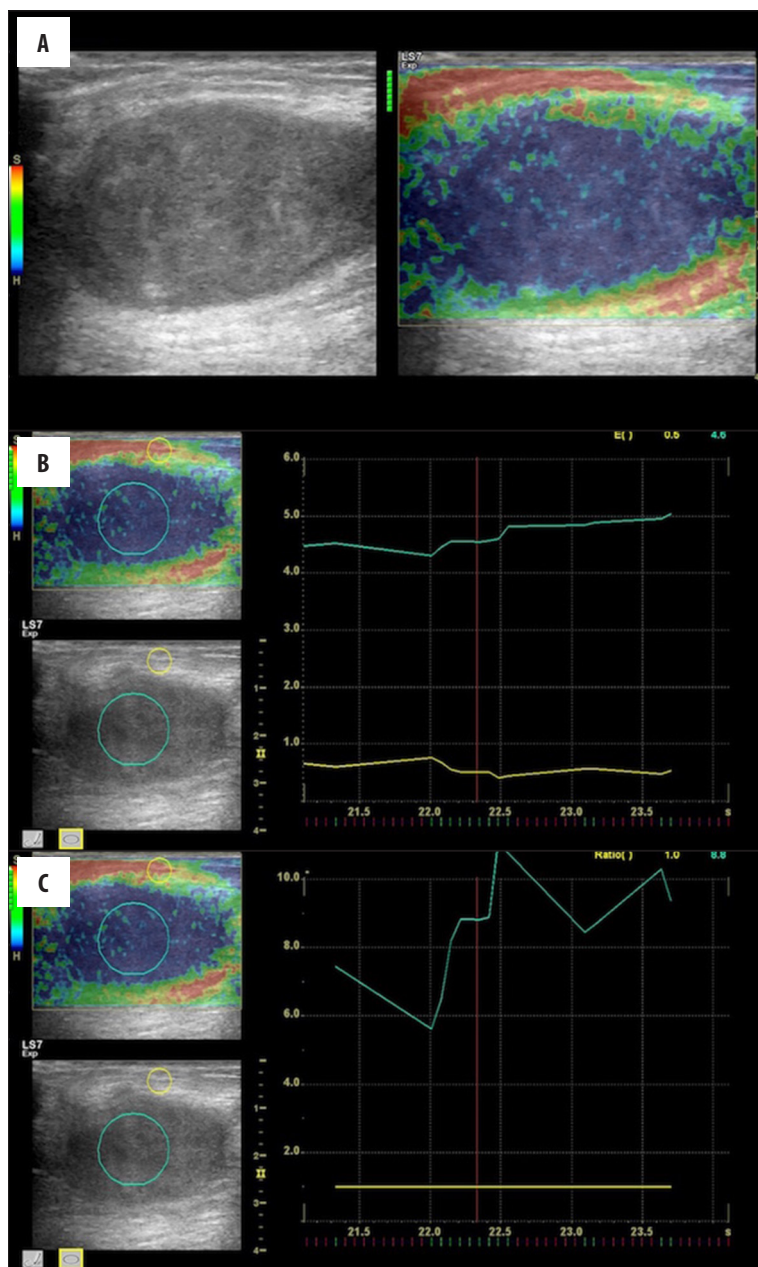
B-mode sonographic image showing a hypoechoic mass with a regular shape (left). Sonoelastographic image showing a predominantly blue lesion (blue color denotes the hardness) (A). Elastographic exam [Q-Analysis by GE Healthcare machine, E-Index (Elasticity Index)] revealed features of hard tissue characteristics with a 4.6 score (measurement range: 0–6; high scores denote the hardness) (B). The mass has a hardness of 8.8 fold compared with subcutaneous fat tissue on elastographic measurement (E-Ratio) (C).
